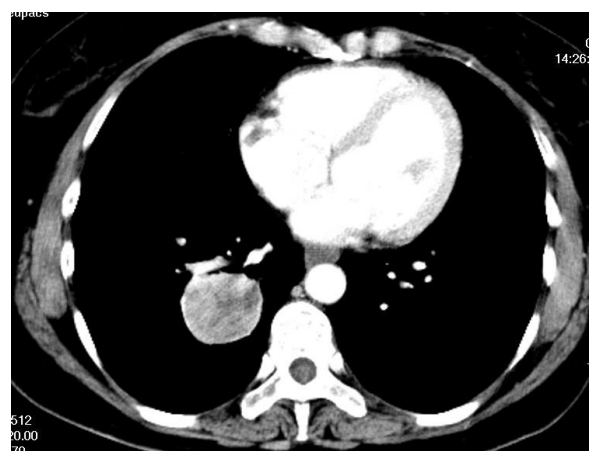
Contrast enhanced CT scan demonstrates heterogeneous enhancement of the lesion.
